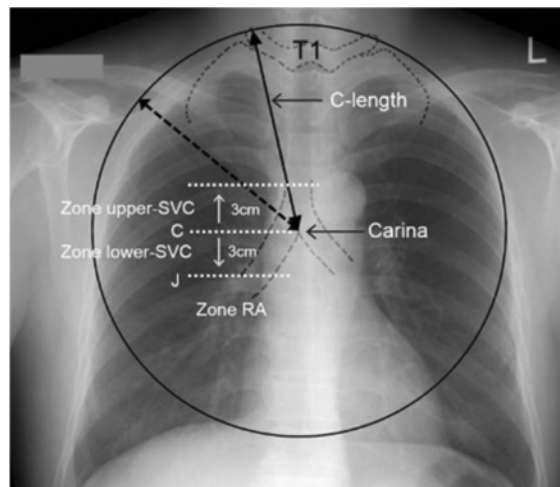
Radiographical hallmark of tip positioning.
